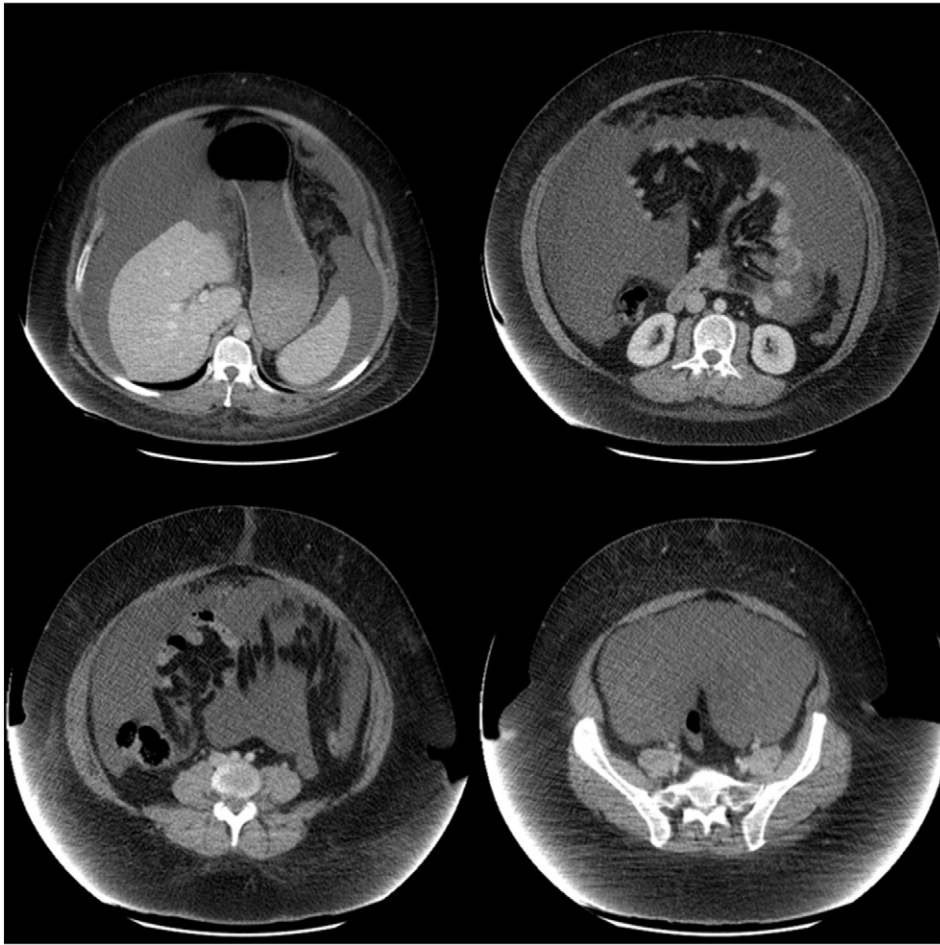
Abdominal and pelvic CT on a patient with adenocarcinoma of the endocervix. Paracentesis resulted in the drainage of 10 l of ascites.
